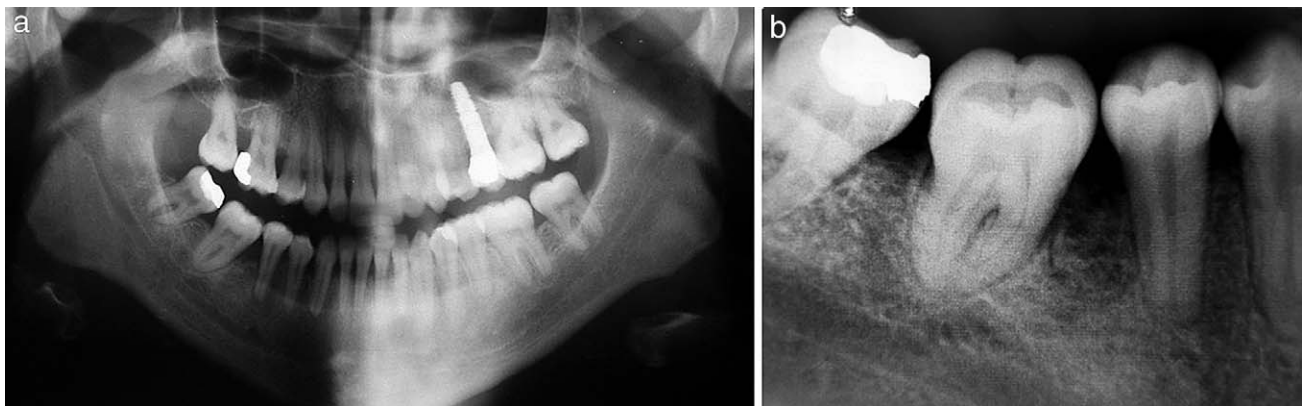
(a) Posttreatment panoramic radiograph. (b) Posttreatment periapical radiograph.
